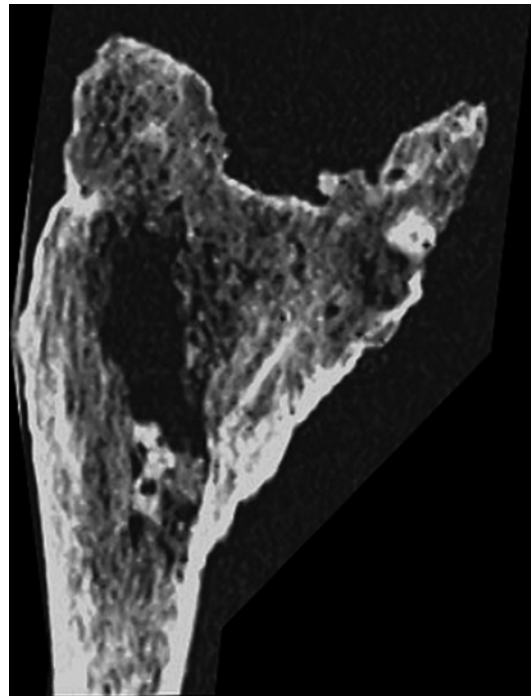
CT scan sagittal plane multiplanar reconstruction
